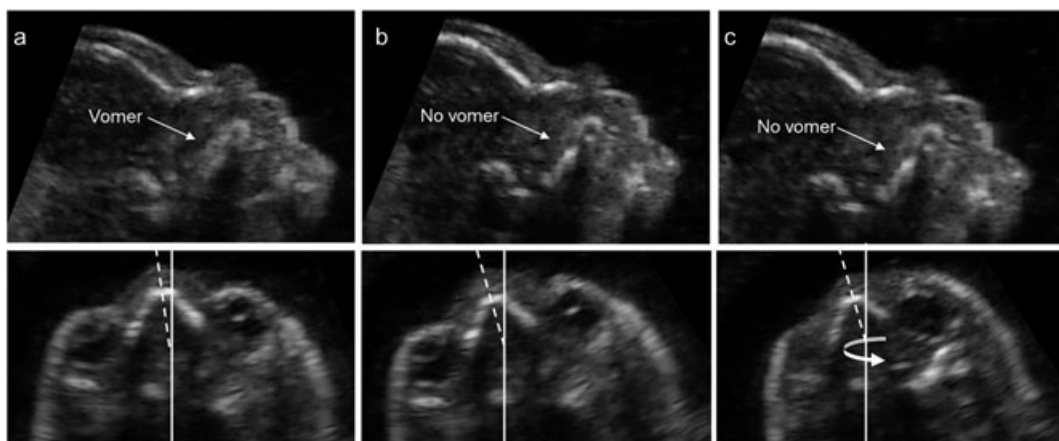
Ultrasound images from a trisomy 21 fetus demonstrating the sagittal and the corresponding transverse plane of the fetal head after rotation away from the exact midsagittal plane around a point placed below the nasal bridge, at the level of the two eye sockets, by 10° along the z-axis (a), 20° along the z-axis (b), a combination of 20° rotation along the z-axis, and 10° along the y-axis (c)
